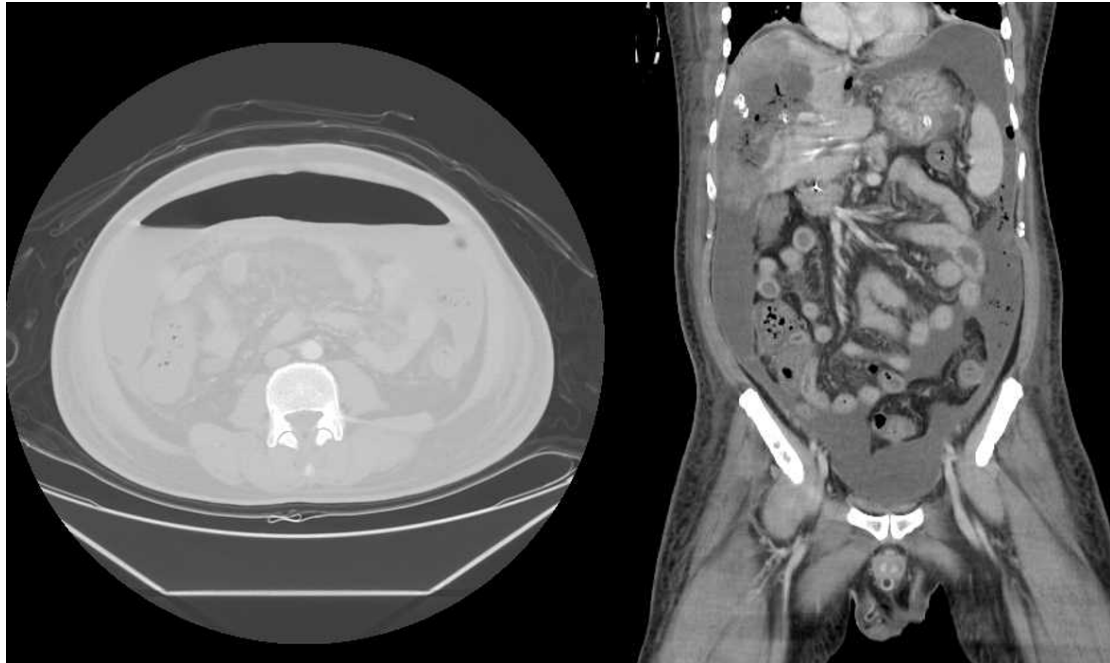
Free air by computed tomography
